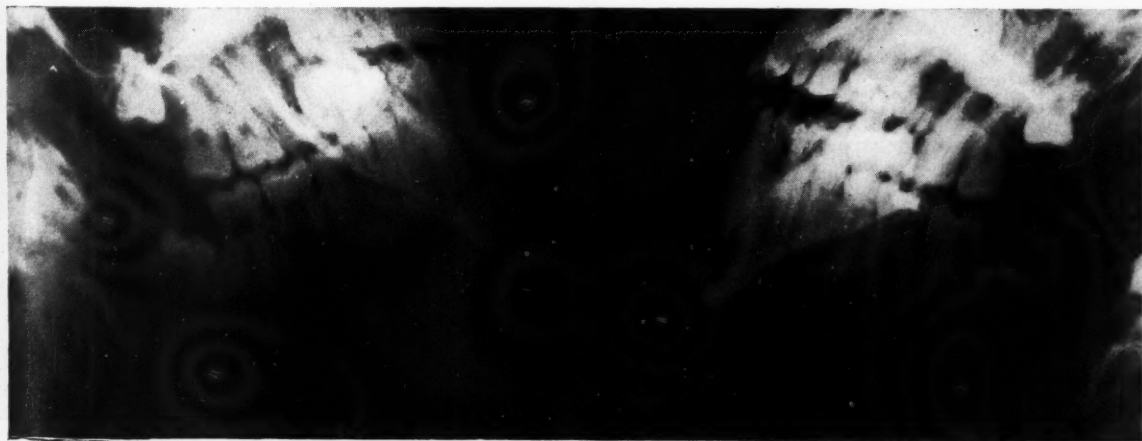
Dental roentgenograms of 19-year-old patient before surgical exposure of right third molar.
